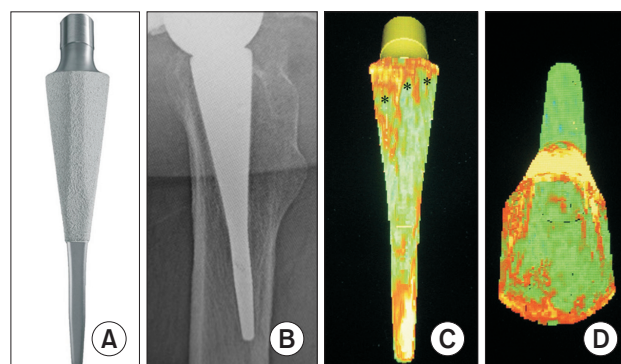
Visual assessment for proximal-lateral corner in Metha by density mapping. (A) Photograph of lateral view. (B) Postoperative radiograph of lateral view. (C) Lateral view. The linear yellow band (black asterisks) was observed in the proximal-lateral corner. (D) The entire surface of the cortical ring was visualized yellow.
